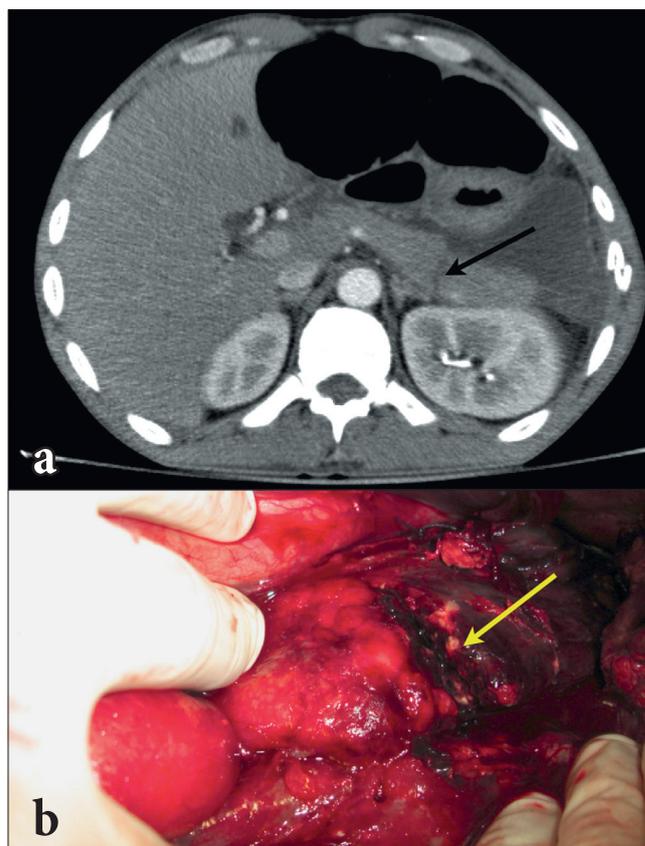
a: Contrast CT scan showing transection of distal pancreas. b: Intra-operative photograph of transected distal body of pancreas (arrow).
